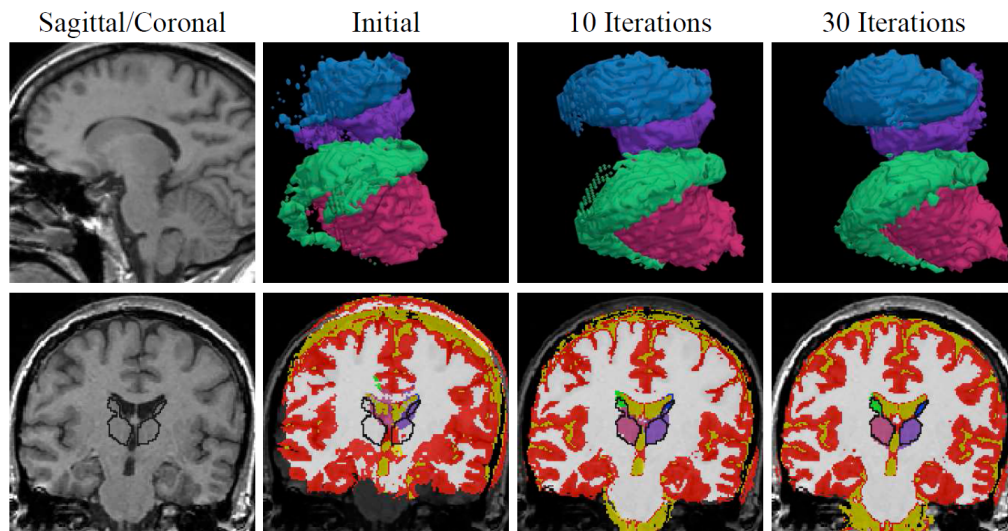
MRI segmentation of the thalamus and caudate using an atlas-based EM segmentation algorithm (Courtesy of K. Pohl).
